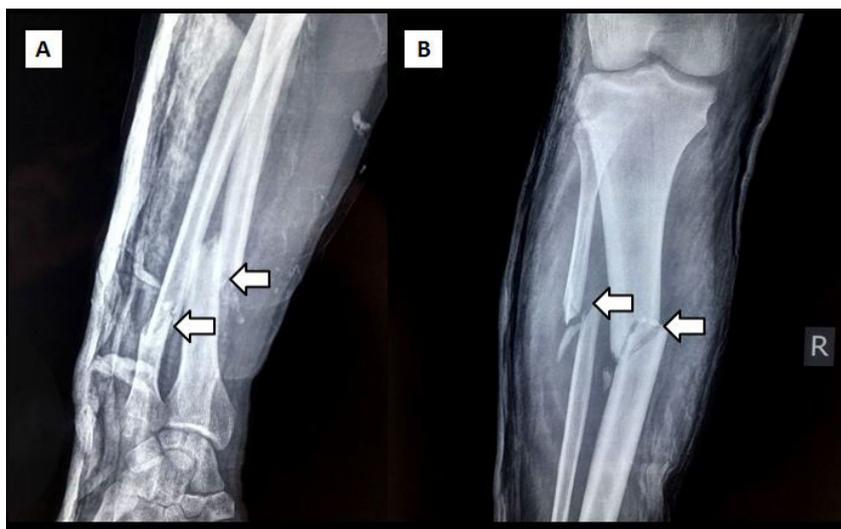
The X-ray showing multiple long bone fractures, including right ulna and radius (A), as well as right tibia and fibula (B).
